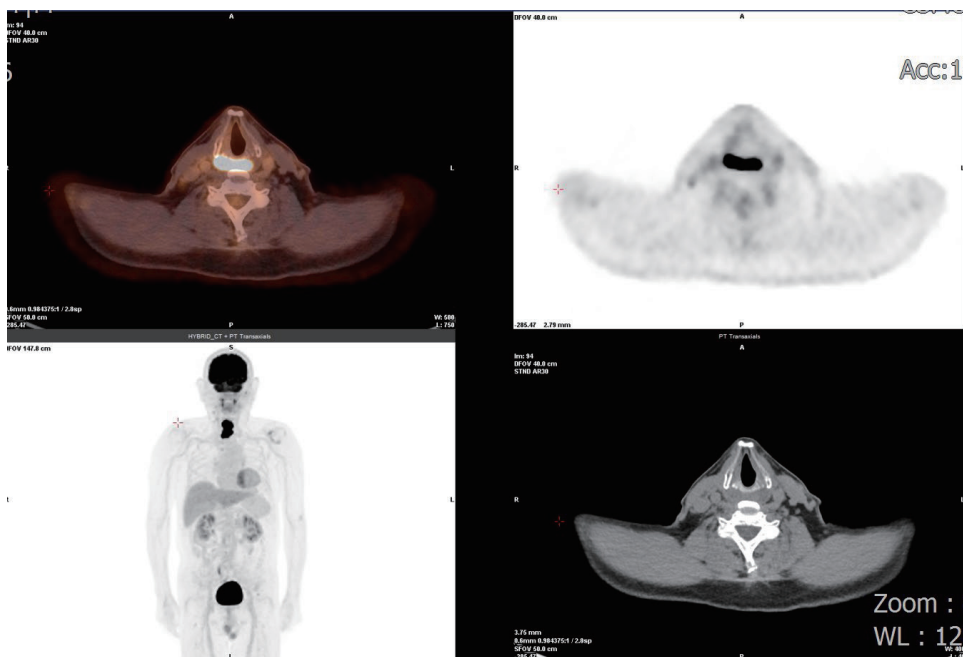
圖一 在正子電腦斷層造影掃描中，影像顯示 ¹⁸F-FDG 葡萄糖異常活度吸收涉及下咽後壁。
